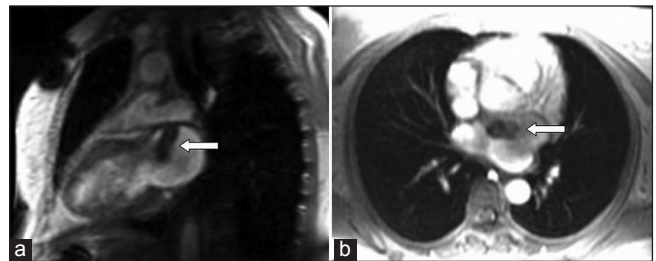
Magnetic resonance imaging of the heart (a, b) showing left atrial myxoma (arrow)
